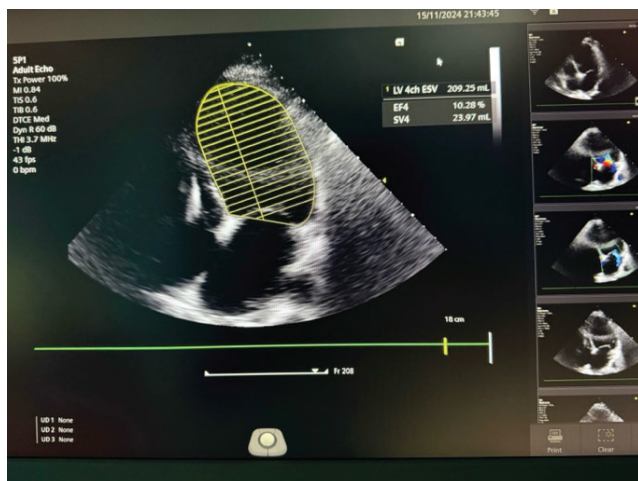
Echocardiography in admission shows low EF with severe global hypokinesis.
